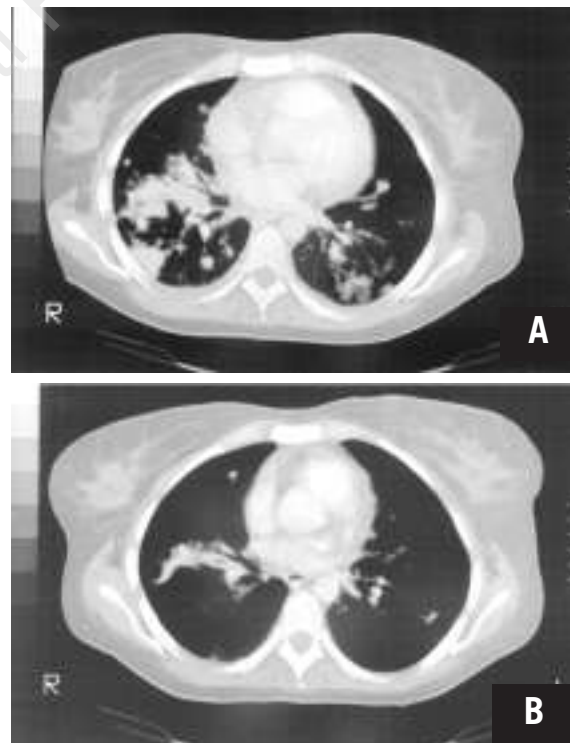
Refractory Hodgkin's disease (chest CT scan). A) Before immunotoxin therapy. Numerous lung tumor nodules are present. B) Seven days after injection of a single dose of Ber-H2/saporin (0.4 mg/kg). Lung tumor nodules have almost completely disappeared. (Reprinted with permission.⁴²)
